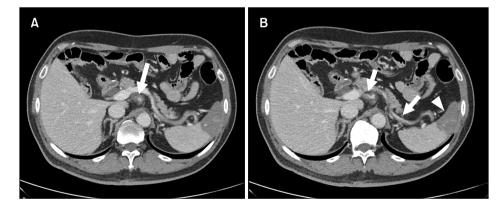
Computed tomography scan revealed (A) celiac artery dissection with intraluminal hematoma (arrow) and (B) dissection extending to the common hepatic and splenic arteries (arrows) with associated splenic infarction (arrowhead).
